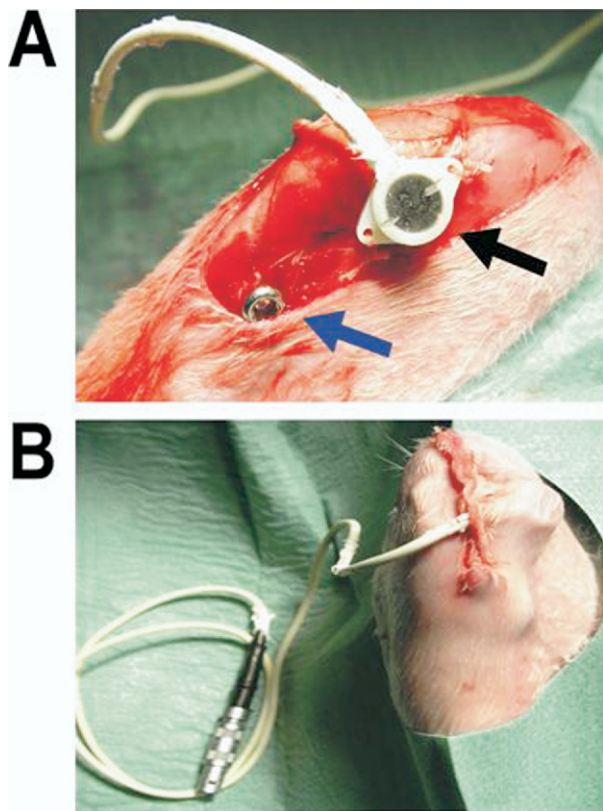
Ultrasound transducer implantation. (A) Anchoring of distal end of the tendon graft on a screw implanted distally to the bone tunnel (blue arrow). The implanted ultrasound transducer onto the bone is indicated by the black arrow. (B) The external overextension of the transducer cable through the surgical wound, which allows ultrasound propagation.
